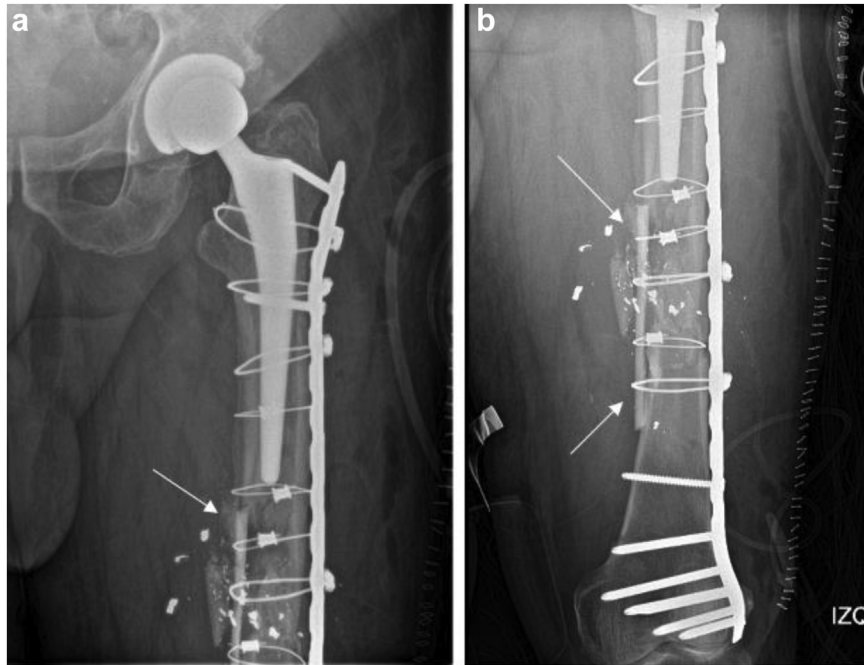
Postoperative anteroposterior (a) proximal and (b) distal left femur radiographs. Cortical alignment can be seen medially (white arrows) fixed with cables.
